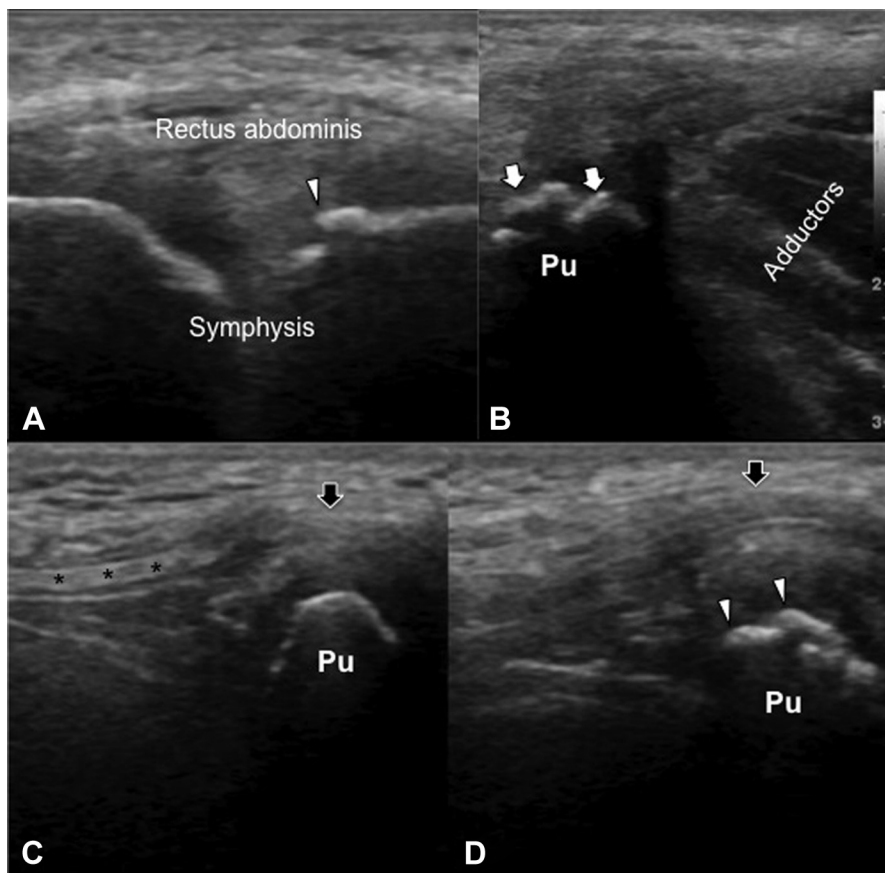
A 20-year-old male professional weight-lifter with groin pain (diagnosed as osteitis pubis). On ultrasound imaging (axial view), a small cortical irregularity (white arrowhead) was detected on the left side of the patient, whereas the transducer was localized on the rectus abdominis muscle attachment on the pubic bone (A). Infrapubic (longitudinal) imaging also revealed left-sided bony irregularities (white arrows) on the insertion of the adductor muscles (B). When compared with the asymptomatic side (C), suprapubic (longitudinal) imaging showed that the rectus abdominis muscle tendon was also irregular and thickened (black arrow), in addition to the cortical irregularities (white arrowheads) (D). Importantly, both areas were tender on sonopalpation. Black stars = a small portion of the rectus abdominis tendon; Pu = pubic bone.
